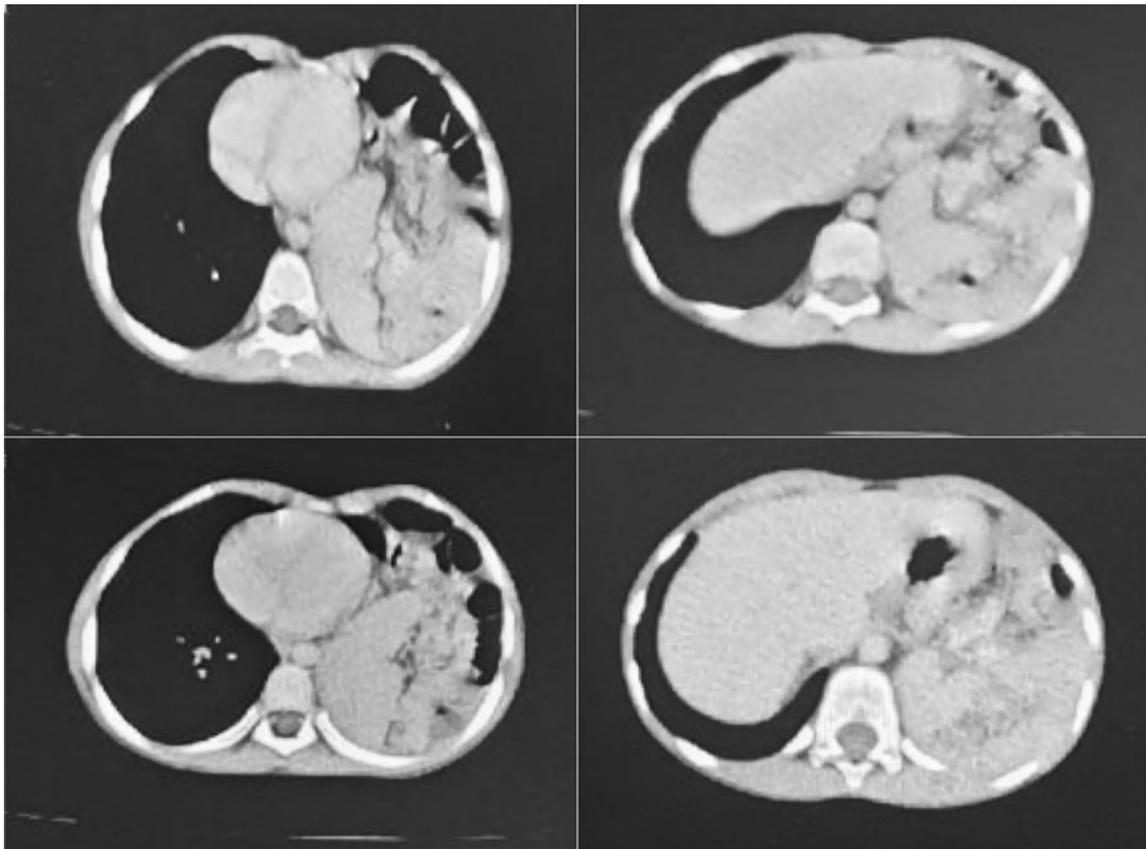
CT scan of the 6 year old male showing collapsed left lung, with note of bowels and spleen in the chest.
